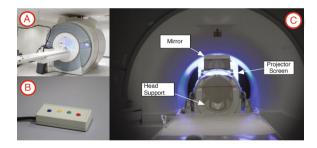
MRI scanner (A), button box (B), and mirror and projector screen (C)
